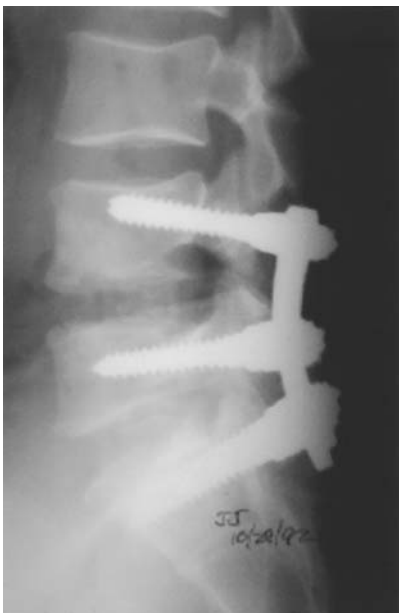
Three-month postoperative lateral x-ray. (From Ref. 33.)
